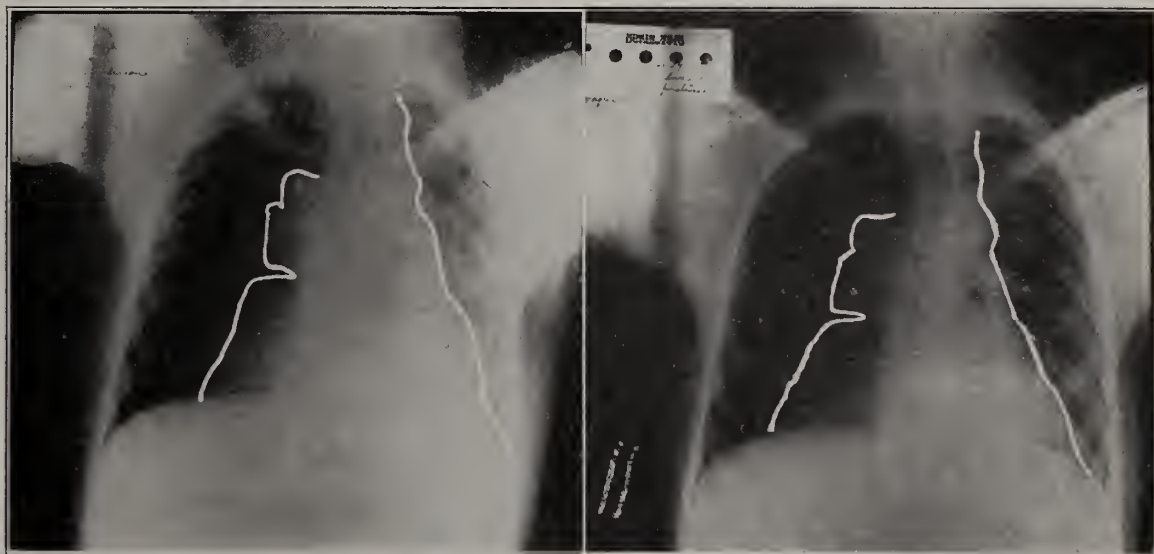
Roentgenograms of chest of W. A. on forced expiration. The right lung has been compressed by an induced pneumothorax. The roentgenogram on the right was taken after paralysis of the right diaphragm. Shifting of the mediastinum to the left is less marked. The intrapleural pressure was the same in each instance.
